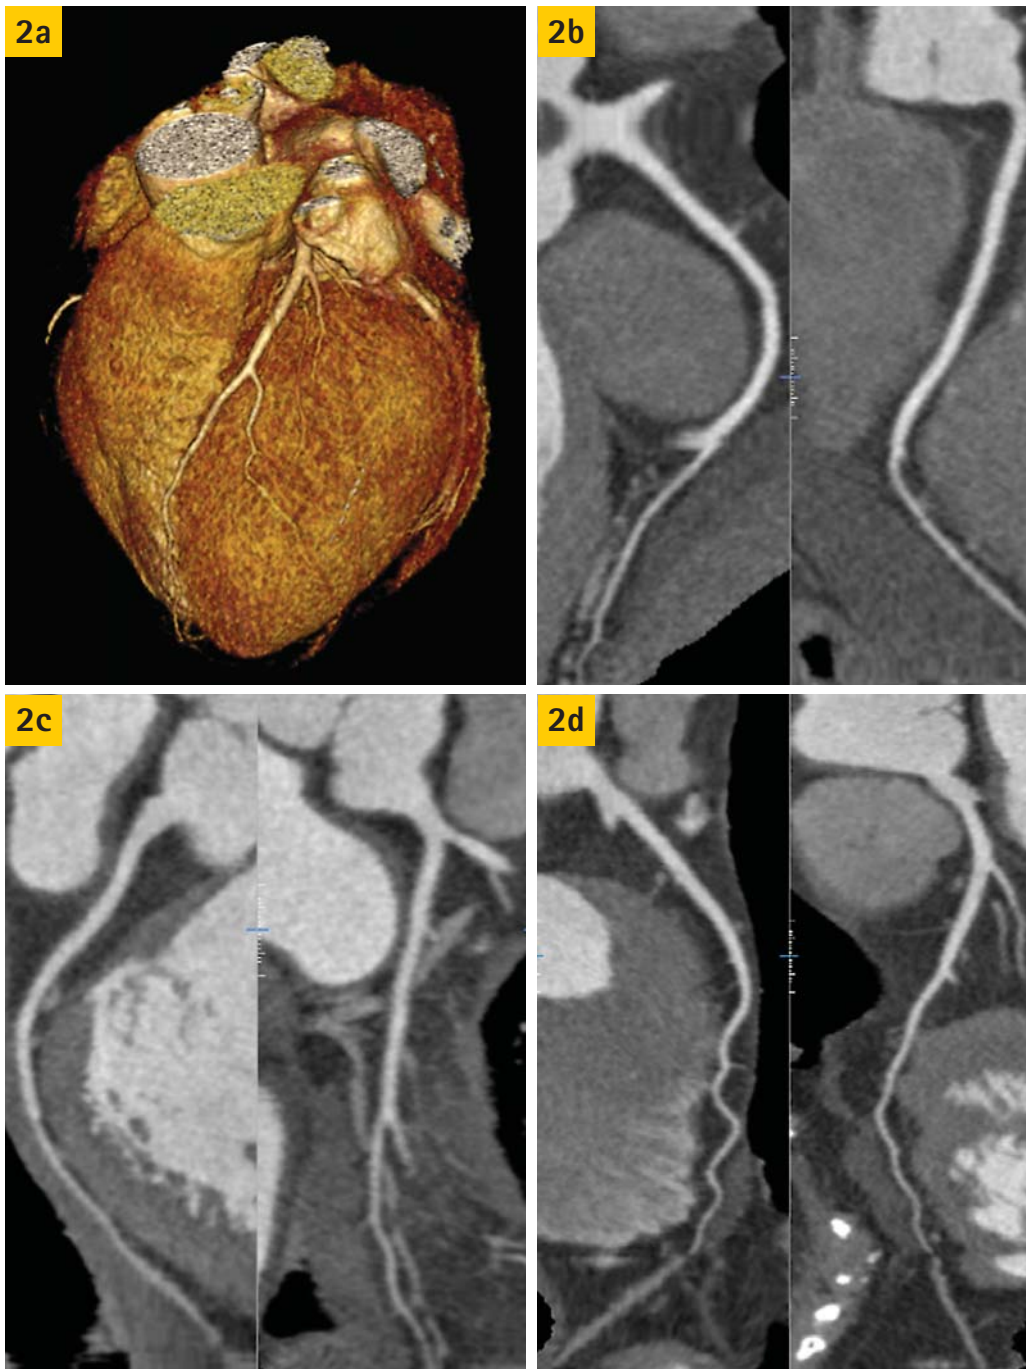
a-d: Cardiac CT with prospective gating: 64-year-old female patient prior to planned Herceptin chemotherapy with visualization of a) 3D-VR, b) RCA-MPR, c) RCX-MPR and d) RIVA-MPR (E=3.1 mSv).
